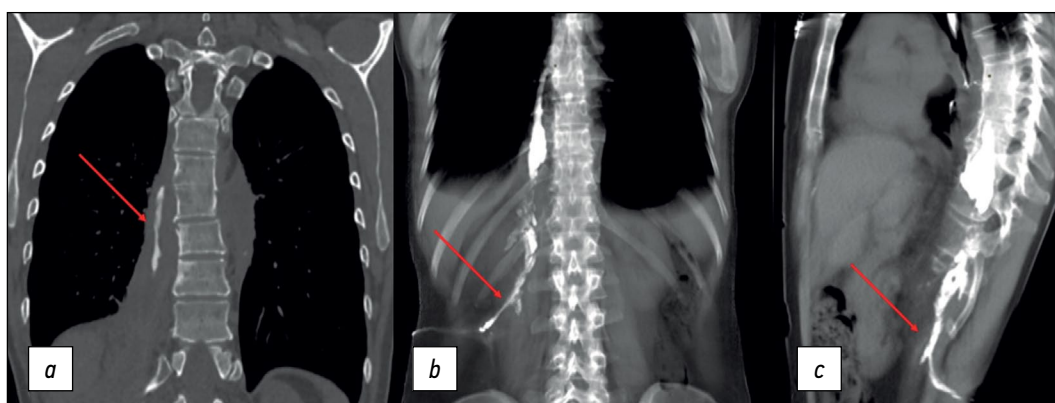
(a) CT esophagography with oral contrast, coronal plane and (b and c) CT fistulography, multiplanar reconstruction (MPR), coronal and sagittal plane. The arrows indicate the fistula tract from the esophagus to the right paravertebral space, from the ThVII to the ThX level.
